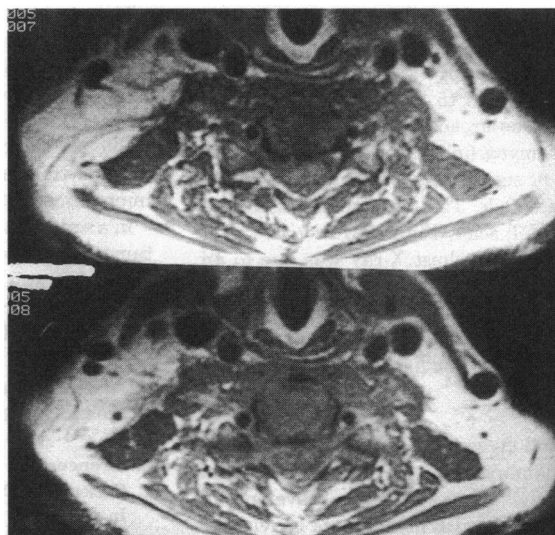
Axial magnetic resonance imaging through C5/6 depicting vertebral osteomyelitis with anterior cord compression
